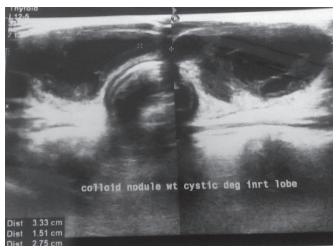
Ultrasonography of the neck showing a heterogeneous lesion with cystic degeneration within the right lobe of the thyroid gland measuring 3.3 cm×2.7 cm×1.5 cm
